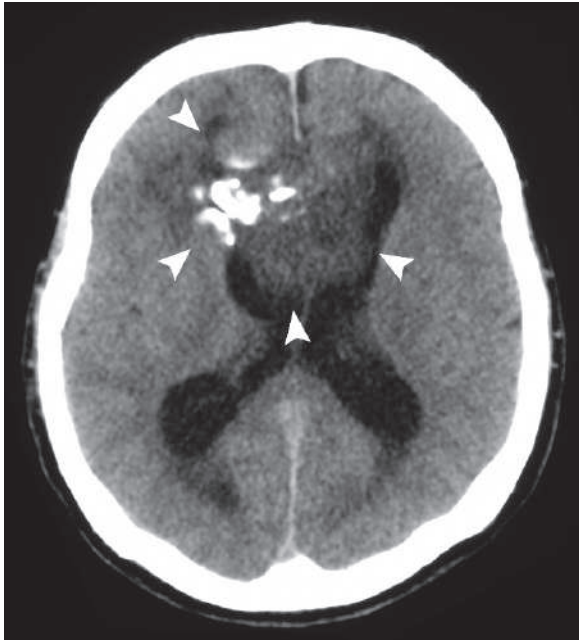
Axial nonenhanced brain CT shows a right frontal lobe tumor that abuts the lateral ventricles (*arrowheads*) and shows areas of dense calcifications (oligodendroglioma)
